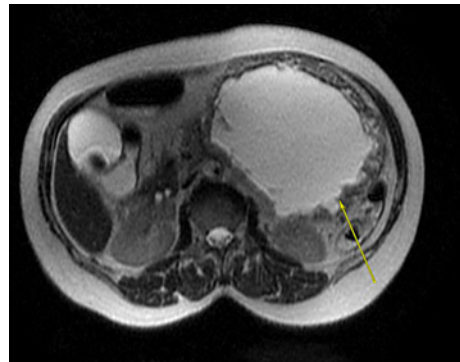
MRI of the abdomen with contrast material (sagittal view) showing a large cystic mass with possible communication with the stomach.
